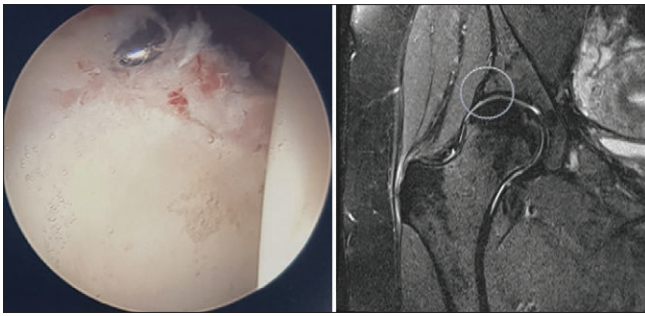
Demonstrates the comparable MRI image to arthroscopic finding of a labral tear. MRI: Magnetic resonance imaging
